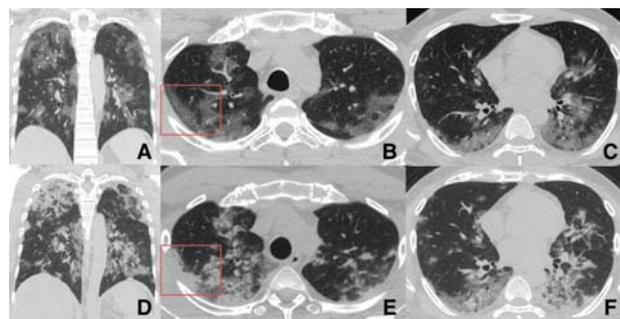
CT images of a 37-year-old patient presented with shortness of breath, fever and cough. His CT at presentation (A, B, C) shows mild peripheral GGO (red box). He had a repeat CT after 4 days due to the increasing requirement of oxygen. This showed progression of the GGO bilaterally into organized consolidation with reticular changes (D, E, F).
